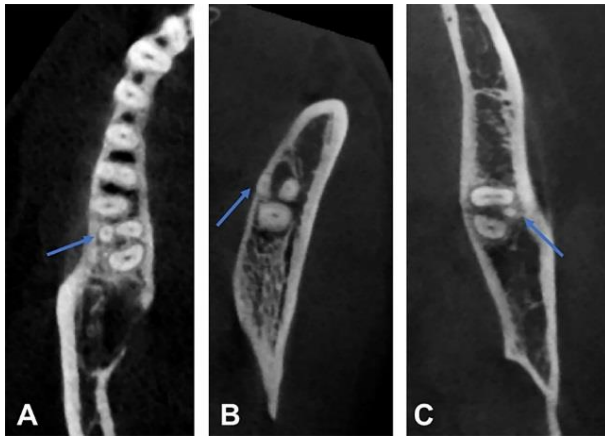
Axial view of a representative CBCT image of mandibular molars with an additional mesio-buccal root of a three-rooted molar (blue arrows); the additional roots are seen as fully developed roots (A, B) or a small appendix (C)
